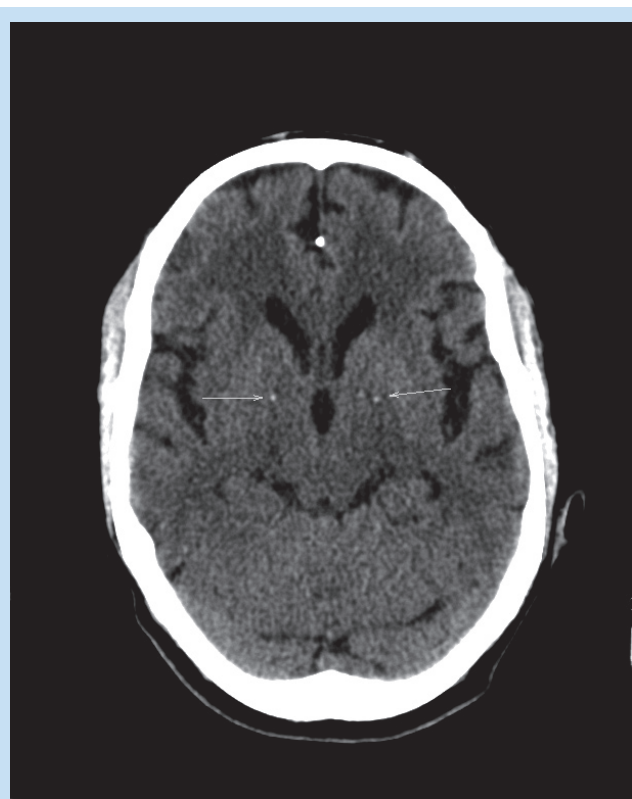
Non-contrast CT scan of a 37-year-old male retroviral disease (RVD) positive patient showing basal ganglia calcification (arrows) and atrophy.
